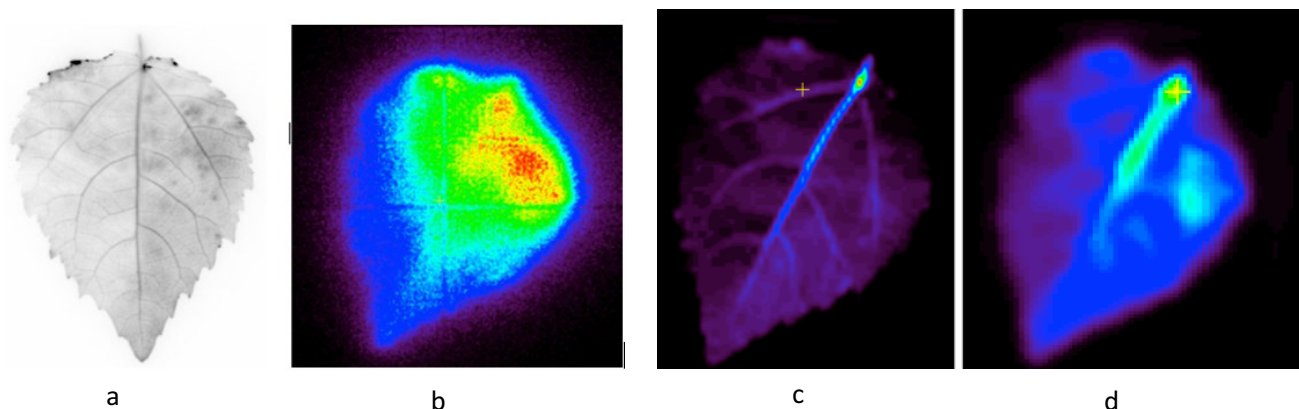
Images of the poplar leaf after administration of ^{18}F fluoride: (a) radiograph with 15 seconds exposure taken after the initial uptake (b) GEM detector image (c) MicroPET image, 20 minute scan after initial uptake at nominal resolution (d) Same MicroPET image blurred to 4 mm resolution
